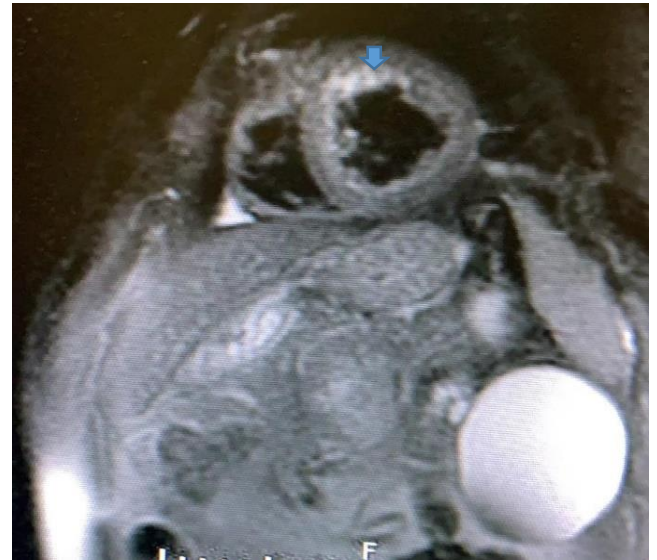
Cardiovascular magnetic resonance images showing late gadolinium enhanced images, with a small area of epicardial hyperenhancement médiopariétal of the side and bottom wall on the 4-chamber view (A) as well as on the short-axis view (B).
